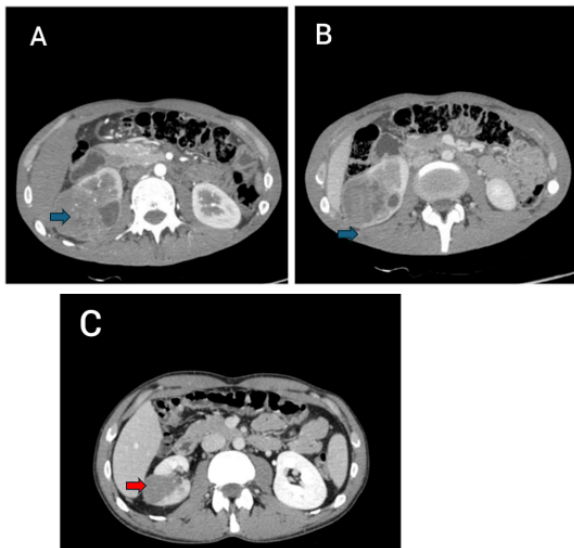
Contrast enhanced computed tomography of abdomen showing right renal mass. (A) Arterial phase showing internal vascularity and (B) Venous phase showing washout (blue arrows). (C) Contrast enhanced computed tomography of abdomen showing Post treatment decrease in size of lesion of right kidney (red arrow).
